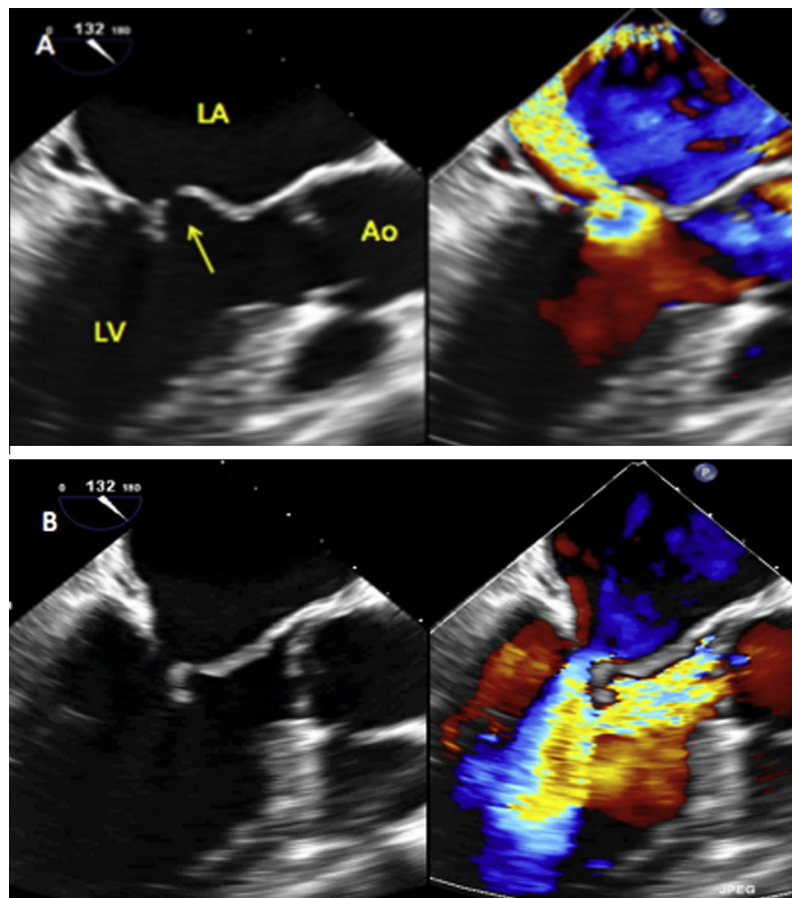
(A) Three chamber TEE view in systole showed aneurysm of A2 scallop and perforation (yellow arrow). Color doppler showed severe regurgitation jet directed posteriorly. (B) View in diastole showed moderate aortic regurgitation jet and relative mitral stenosis jet (LA: left atrium, LV: left ventricle, Ao: Aorta).
